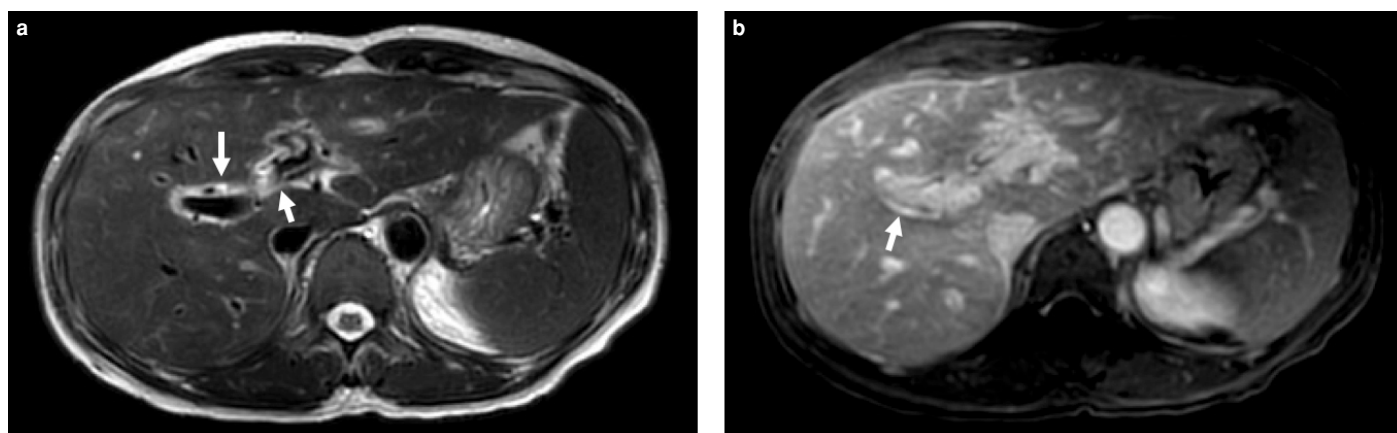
Abdominal MRI shows thickening and enhancement of the intrahepatic and common hepatic bile duct walls. (a) An axial T2-weighted image shows wall thickening of the intrahepatic bile duct (arrows). (b) An axial T2-weight image taken 5 minutes after Gadolinium injection shows enhancement of the wall thickening in the intrahepatic bile duct (arrow).
